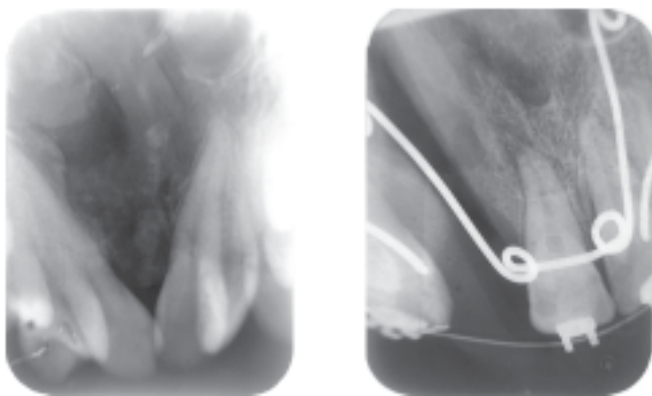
Periapicals showing a Bergland Index score of 1 and 4.
